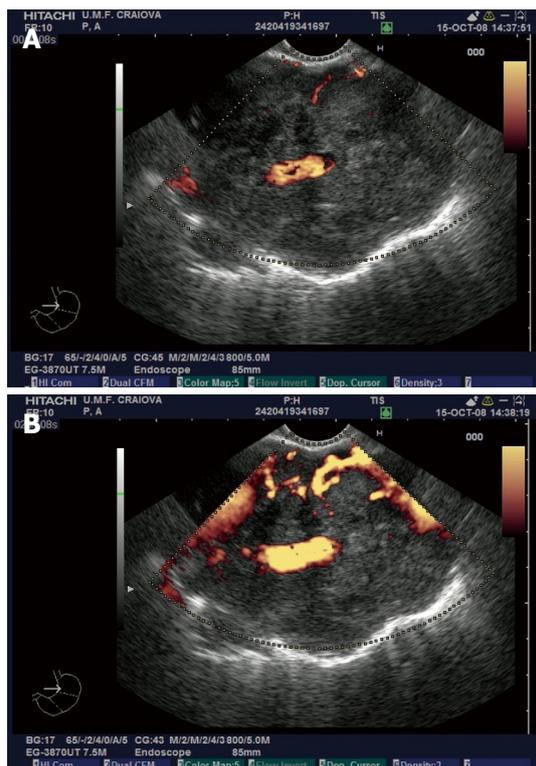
Contrast enhanced endoscopic ultrasonography exam of lung adenocarcinoma. A: Non-enhanced power Doppler image of a lung adenocarcinoma visualized in the aorto-pulmonary window from the mid-esophagus, with discrete Doppler signals in the periphery of the mass and embedding of a large branch of the left pulmonary artery; B: Same tumor visualized after contrast-enhancement with SonoVue, with a better depiction of the vascular peripheral signals and the possibility of quantification of the vascular index. The relationship to the aorta and pulmonary artery is clearly depicted.
